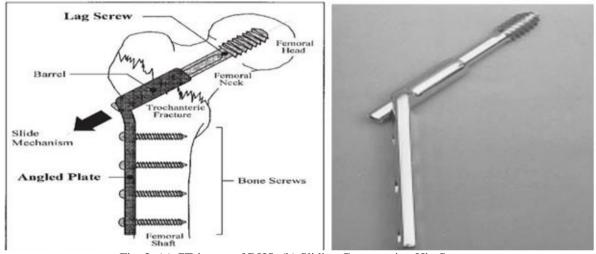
(a) CT-image of DHS, (b) Sliding Compression Hip Screw
